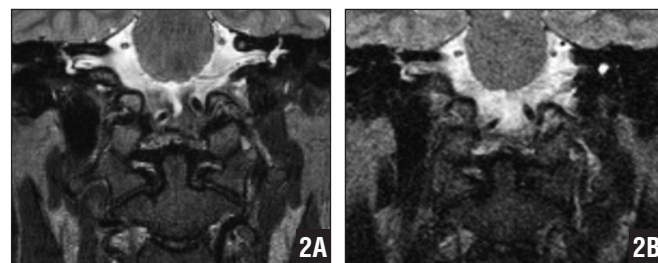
Three-T (A) and 1.5-T (B) magnetic resonance images showing the overall higher signal-to-noise ratio on 3-T imaging.
